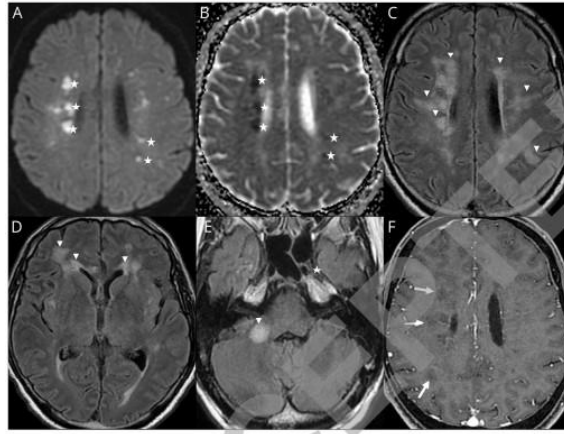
Radiological ADEM. Axial FLAIR (a,e,i), axial diffusion (b,f,j), Apparent diffusion coefficient (ADC) map (c,g,k) and post-contrast T1 (d,h,l) weighted MR images. Man aged 60 years: Subcortical, periventricular, corpus callosum, and posterior fossa white matter FLAIR hyperintensities, without contrast enhancement (arrows). Some lesions appear hyperintense on diffusion-weighted MR images with decreased ADC corresponding to cytotoxic edema (stars). The other lesions present an ADC increase corresponding to vasogenic edema (cross).
